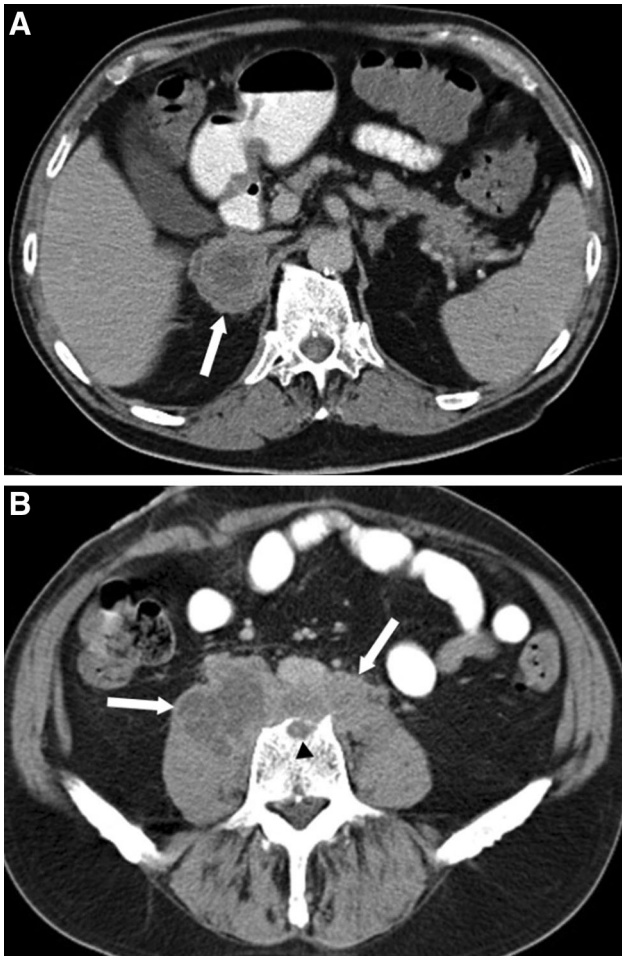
71-year-old man with history of urothelial carcinoma of the bladder with typical sites of metastatic disease. A Axial contrast-enhanced CT image show a heterogeneously enhancing right adrenal gland mass (*white arrow A*), consistent with metastasis. B Axial contrast-enhanced CT image shows a large retroperitoneal nodal conglomerate (*white arrows B*) with focal bone destruction in the anterior aspect of the vertebral body (*black arrowhead B*), representing nodal metastases.
